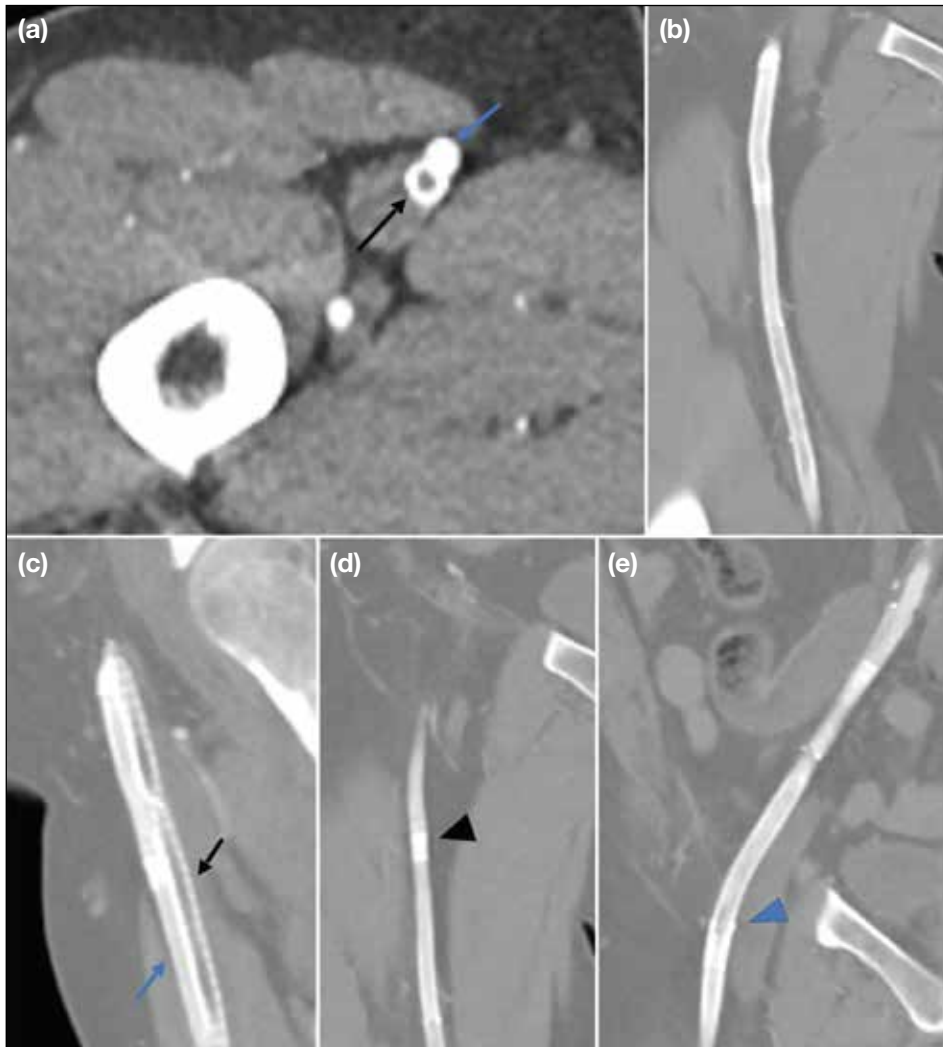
Follow-up computed tomography angiogram at 8 months postprocedure showing successful double-barrel stenting with exclusion of the mid superficial femoral artery (mid-SFA) Zilver stent (black arrows in [a] and [c]) and a patent new Supera mid-SFA stent (blue arrows in [a] and [c]): (a) axial view; (c) oblique sagittal view. Oblique coronal reconstruction showing patency throughout the intraluminal-subintimal-intraluminal multi-stent system (b), including the distal overlapping stent segments (black arrowhead in [d]) and the proximal overlapping stent segments (blue arrowhead in [e]).
